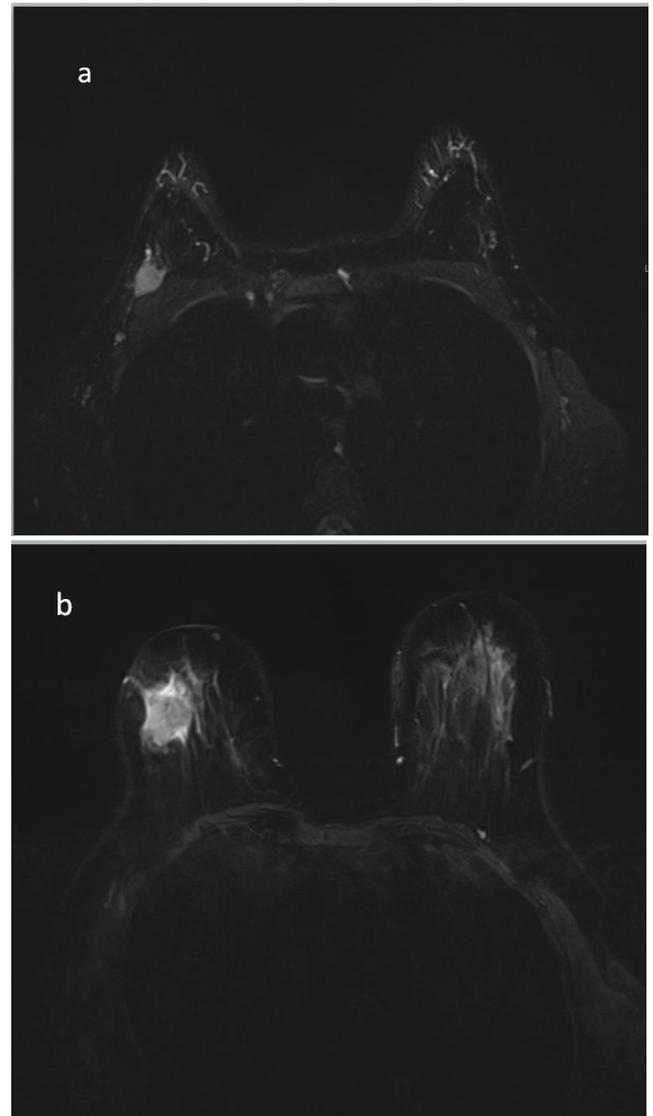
a,b. Fat-suppressed T2-weighted axial breast MR image in a 45-year-old woman with triple-negative invasive ductal carcinoma. Ki67 labelling index was 60 and no peritumoral edema was shown (a). Fat-suppressed T2-weighted axial breast MR image in a 35-year-old woman with triple-negative invasive ductal carcinoma. Ki67 labelling index was 35 and presence of peritumoral edema was shown (b).
